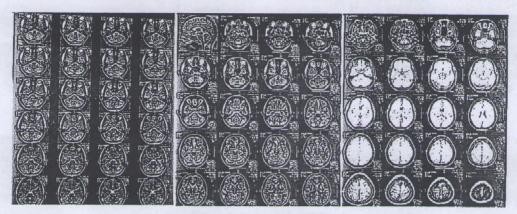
MRI within normal limit
